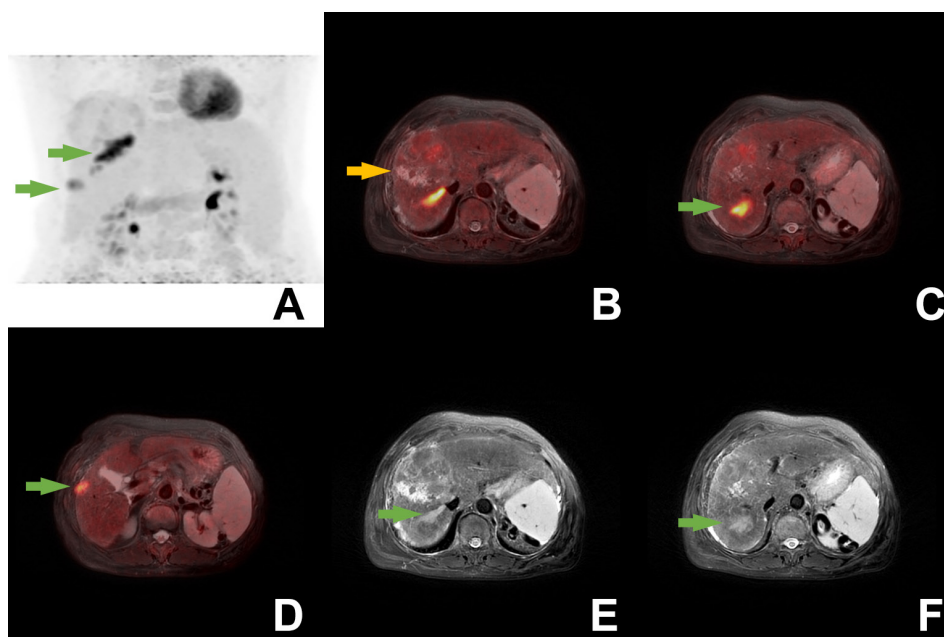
After 9 months of sorafenib treatment AFP levels were measured as low as 801 ng/mL. Post-treatment integrated ^{18}F -FDG PET/MRI revealed that diffuse infiltrating lesions had largely regressed. A few ^{18}F -FDG-avid lesions (green arrows) with maximum SUV_{max} : 10.9 including tumor thrombosis in right hepatic vein, could be visualized in MIP (A), axial T2-weighted MRI (E, F), axial PET/MRI fusion (B, C, D) images. There was no significant difference in MRI findings of large mass as it had a minimal decrease in diameter to 8 cm and is still mildly ^{18}F -FDG-avid (B-orange arrow).
